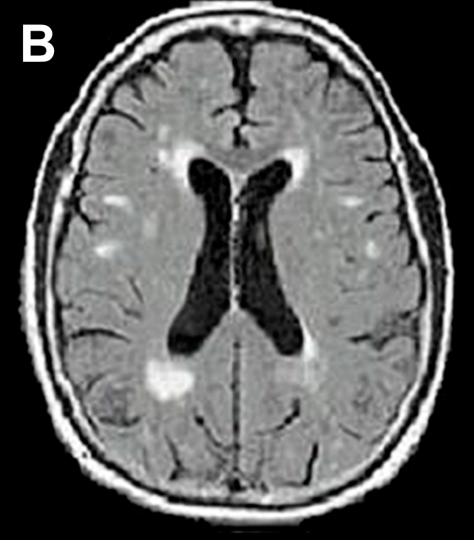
FLAIR MRI of a brain without WMH (A) and one with WMH (B)
